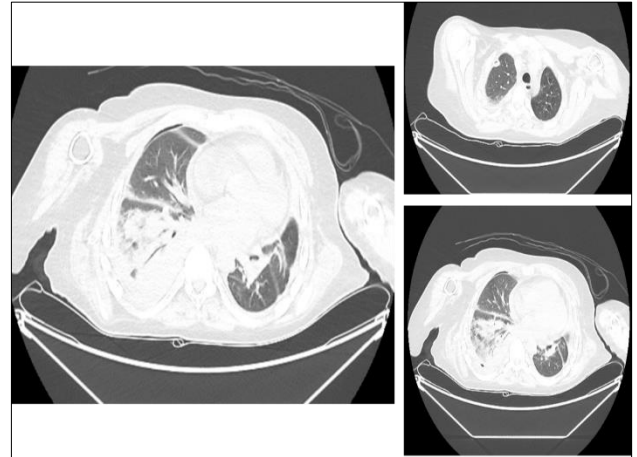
Lung CT on the 6th day of hospitalization.
